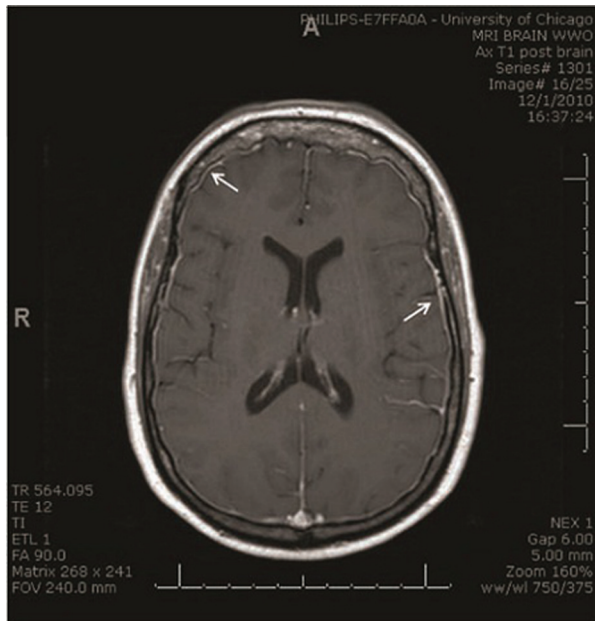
Axial section of postcontrast T1-weighted brain MRI image showing the dural thickening with gadolinium-contrast enhancement (arrow).
